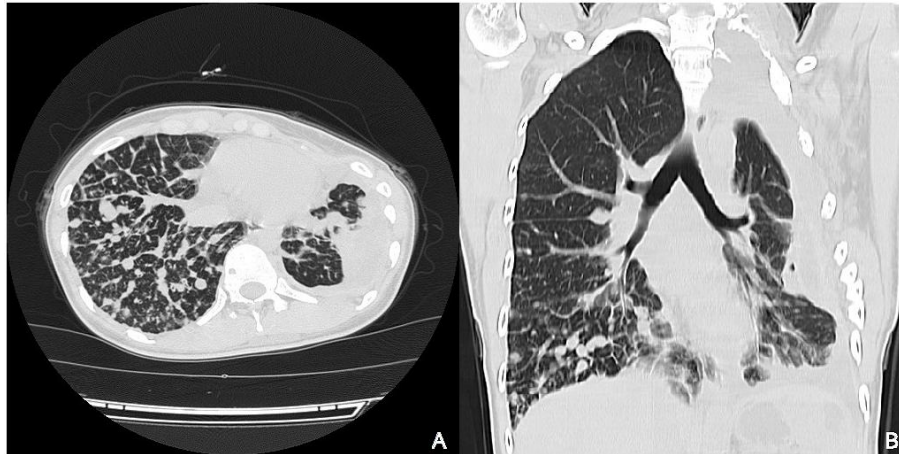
A 23-year-old female patient, pulmonary HRCT in 2016 showed diffuse nodules of different sizes in the right lung, reticular thickening of the interlobular septum, collapse of the left chest and reduction in the volume of the left lung. A) Horizontal plane. B) Coronal plane.
